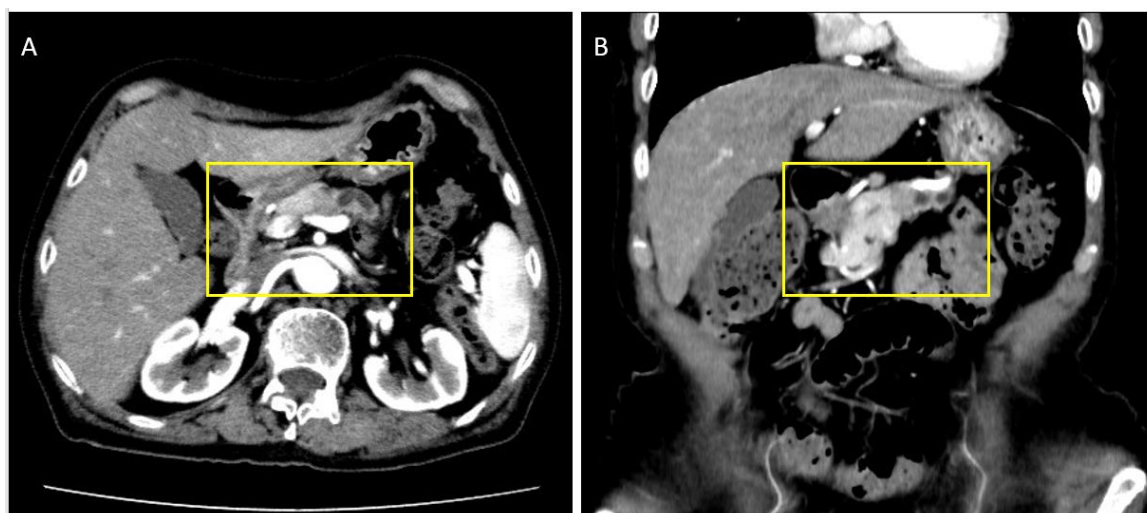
Abdominal CT Findings
